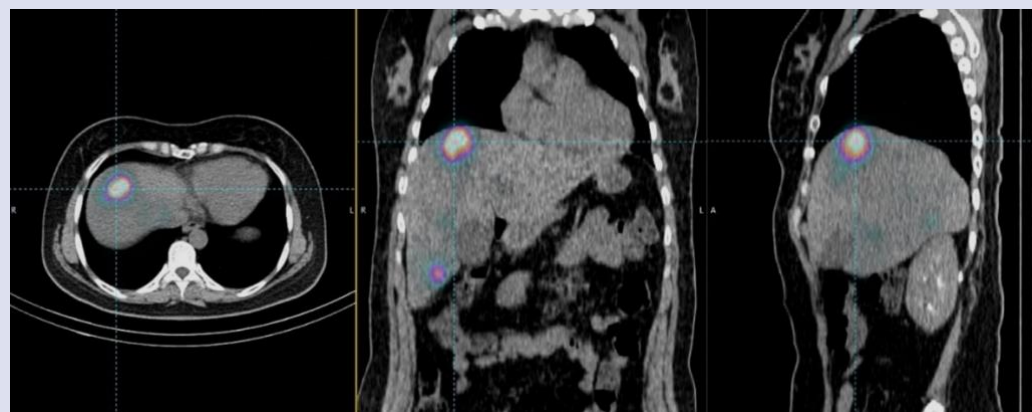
Short-axis, coronal, and sagittal cross-sectional views from left to right of PET/CT images taken after 90Y microsphere treatment, showing tumors in the patient's liver. Yellow, blue, and red colors respectively indicate liver, lung, and tumor.
